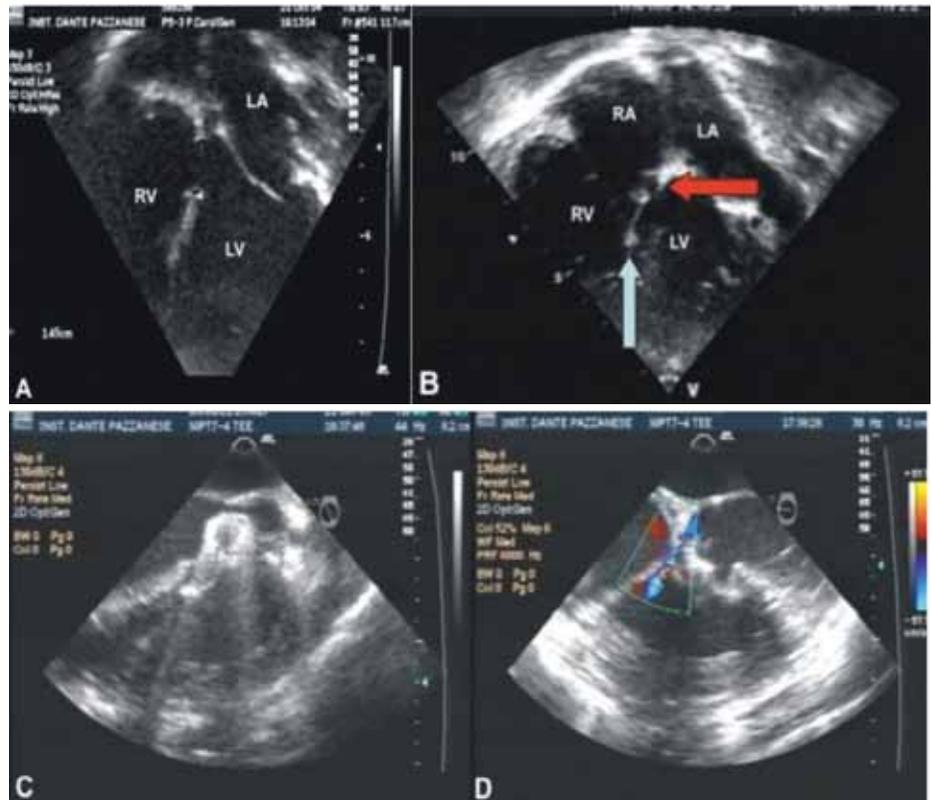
Echocardiographic pictures of the defect. (A) Four chamber view (pre-operative TTE): Large PM VSD with inlet extension measuring 14 mm at its maximal diameter. (B) Modified four chamber view (post-operative TTE): There is a residual VSD (red arrow) measuring 5-6 mm at the superior portion of the patch (light blue arrow), near the crux of the heart and the AV valves. (C) Long axis view (TEE during the percutaneous procedure): The left ventricular loops of the PFM Nitinol coil are protruding into the LVOT. (D) Long axis view (TEE during the percutaneous procedure): The Amplatzer membranous VSD occluder is well positioned after final release. There is a small residual leak through the superior aspect of the device.
